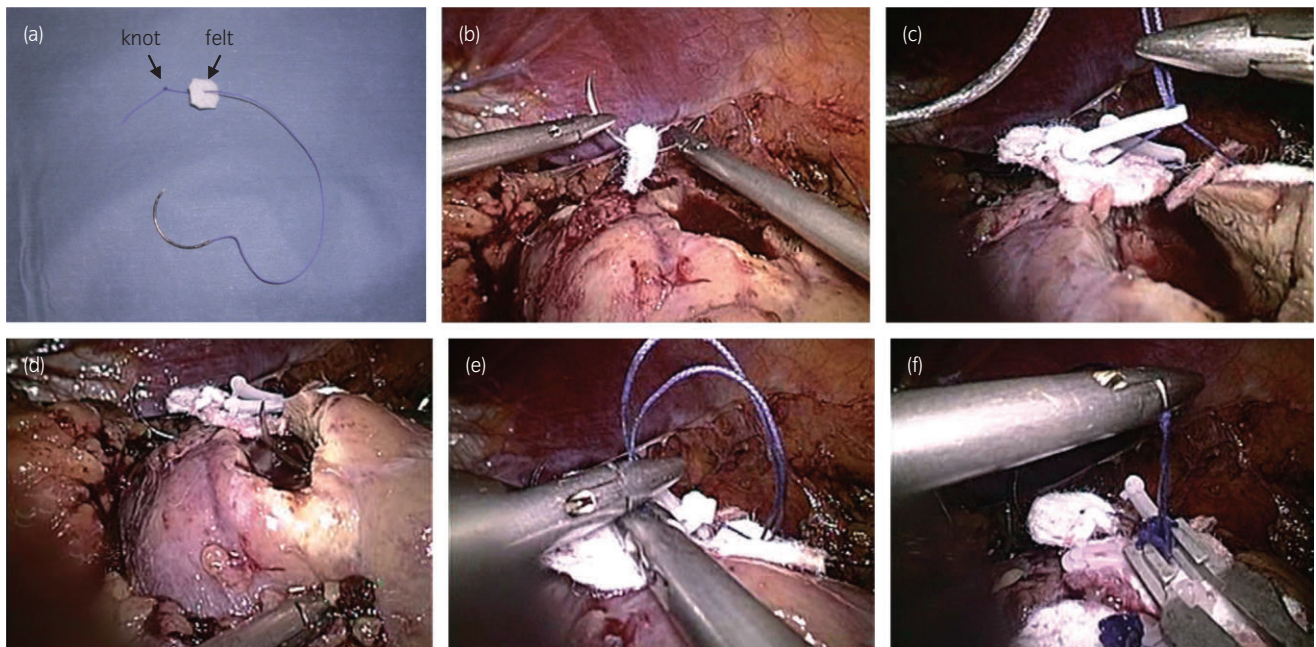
Steps of the interrupted suture with ligation using felt, a Hem-o-lok and Lapra-Ty. (a) Double knots are made 2 cm from the terminal end of 18 cm of 2-0 Vicryl with a CT-1 needle. A 1.2×1.2 cm piece of felt is attached on the proximal side of the knots. (b) Once each suture is done, the felt is applied through the needle. The suturing is started from the back of the wound. (c) Both threads are temporarily held using an L-size Hem-o-lok. It is crucial to make an isosceles triangle-shape between the threads. (d) All sutures can be carried out under a clear view of the bottom of the wound, because the threads are not fully tightened yet. (e) The threads are fixed by sliding the Hem-o-lok using the needle holder. Care should be taken not to flip or dislocate the felt. (f) Then both threads are locked using the Lapra-Ty. Fixing and locking are sequentially carried out from the front to the back of the wound. Before cutting out the needles, the vascular clamps are removed and hemostasis is observed. Bleeding from the wound after declamping can usually be controlled by compression with gauze and the application of fibrin glue. It should be kept in mind that many sutures are required for a long wound, because the sutures are carried out at intervals of 1 cm. Thus, as the wound becomes longer, more time for suturing is necessary.
